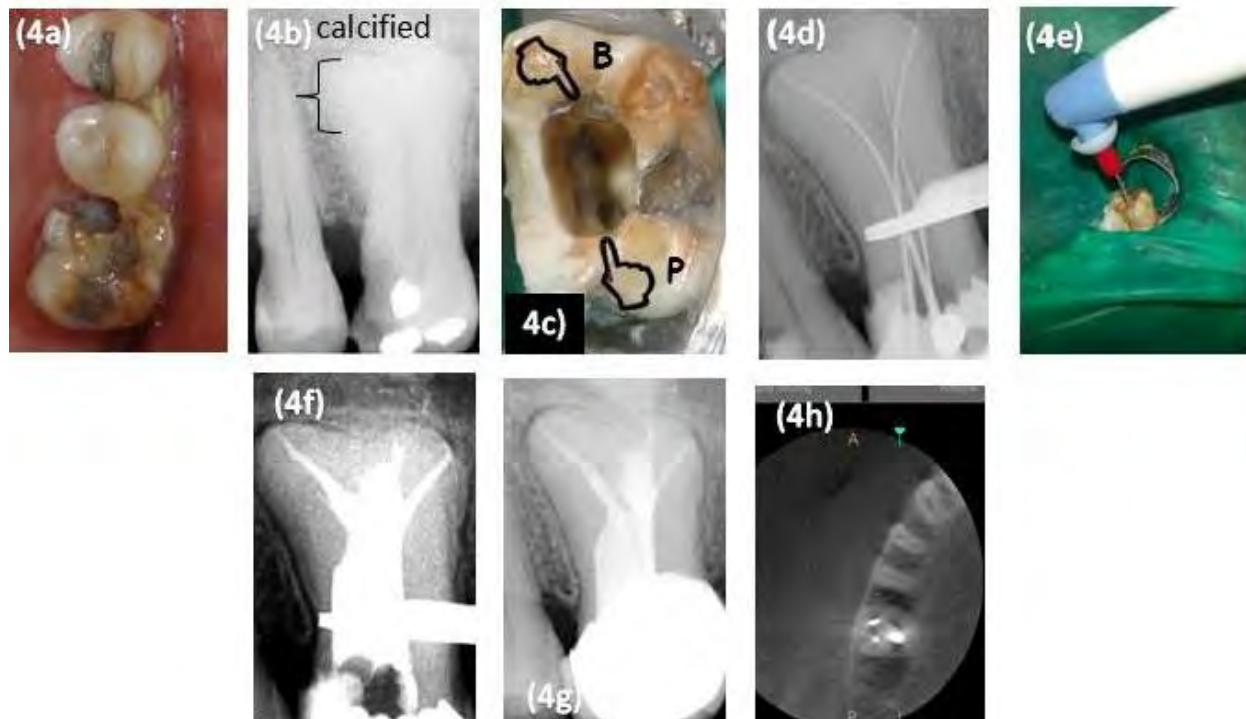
Tooth #16. (4a) Intraoral view (4b) Pre-operative IOPAR, (4c) Buccal and palatal canal orifices, (4d) WL IOPAR, (4e) Sonic activation with Endoactivator, (4f) Obturation done using obtura II (4g) Post-operative IOPAR with crown, (4h), Post-operative CBCT axial view
